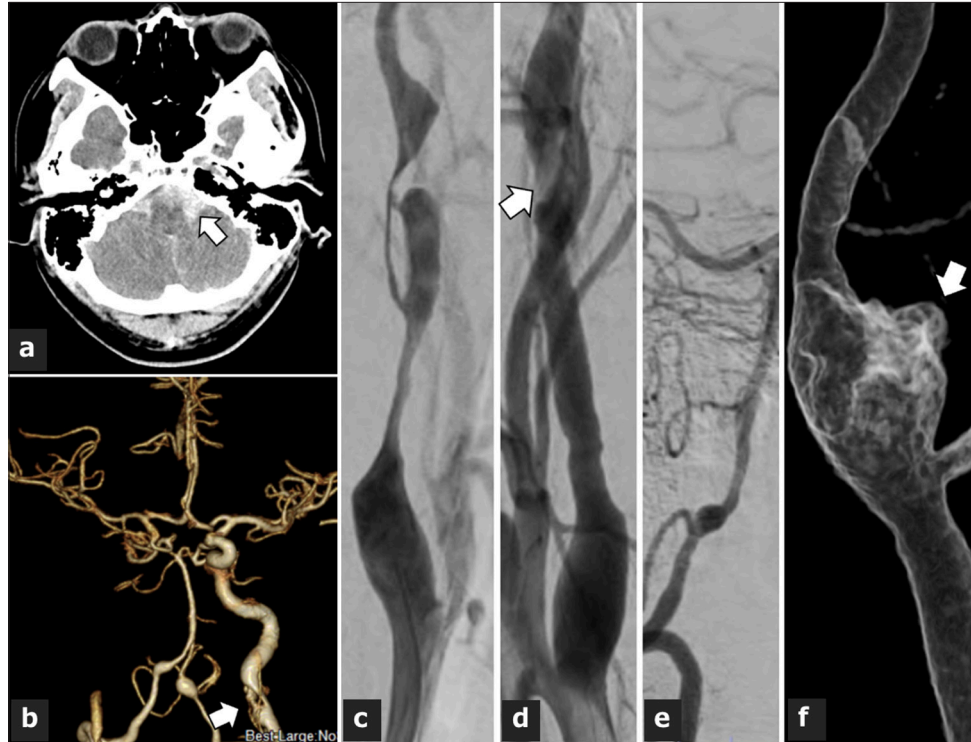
(a) Computed tomography showed a thick subarachnoid hemorrhage around the left vertebral artery (arrow). (b) Computed tomography angiography revealed dissections in the bilateral internal carotid arteries and vertebral arteries. The right internal carotid artery was occluded, while the left internal carotid artery showed a partial deficiency, likely due to a thrombus associated with dissection (arrow). Fusiform aneurysms were observed in both vertebral arteries. (c) Digital subtraction angiography demonstrated recanalization of the right internal carotid artery. (d) The left internal carotid artery had poor contrast (arrow). (e) The right vertebral artery displayed a fusiform aneurysm. (f) The left vertebral artery had a fusiform aneurysm with a bleb (arrow).
